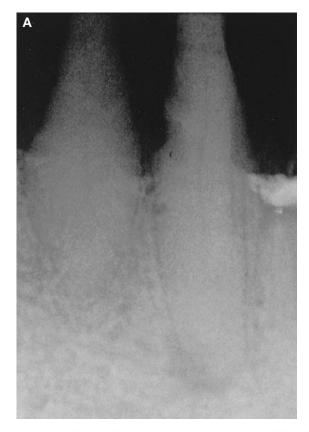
(A) Preoperative radiograph for tooth No. 23 showing an apical bifurcation. The tooth has been prosthetically prepared before the root canal. (B) Postoperative radiograph for tooth No. 23. Note the small access cavity to preserve the prosthetic preparation and the management of the apical bifurcation.
